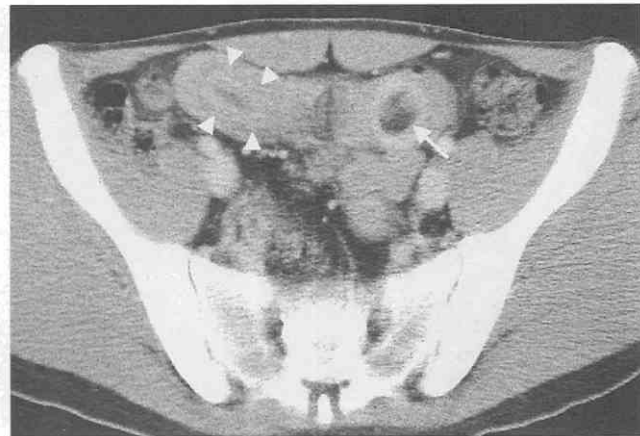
Ileal lipoma with intussusception. CT scan shows a "bowel-within-bowel" appearance (*arrowheads*). A lipomatous mass (*arrow*) can be seen at the leading point.
